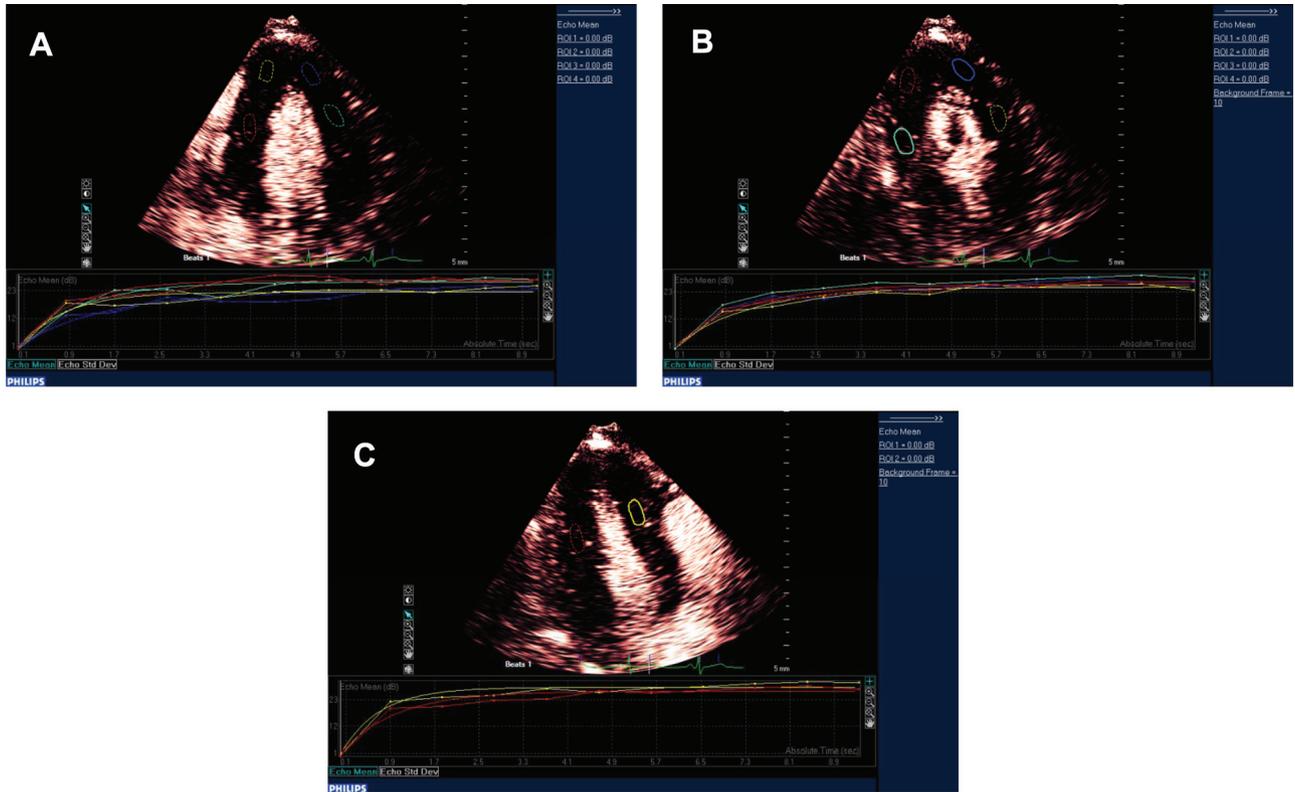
Model used for quantitative analysis of myocardial segments. A, Apical 4 chamber; B, apical 2 chamber; C, apical 3 chamber.
